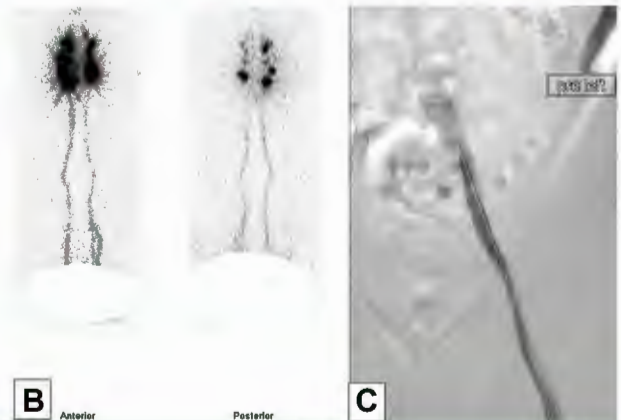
Unreliability of clinical signs of lymphedema. A, Mimicry of clinical signs of lymphedema with venous obstruction. B, Normal lymphoscintigram. C, Femoroiliacaval obstruction noted on venogram.
